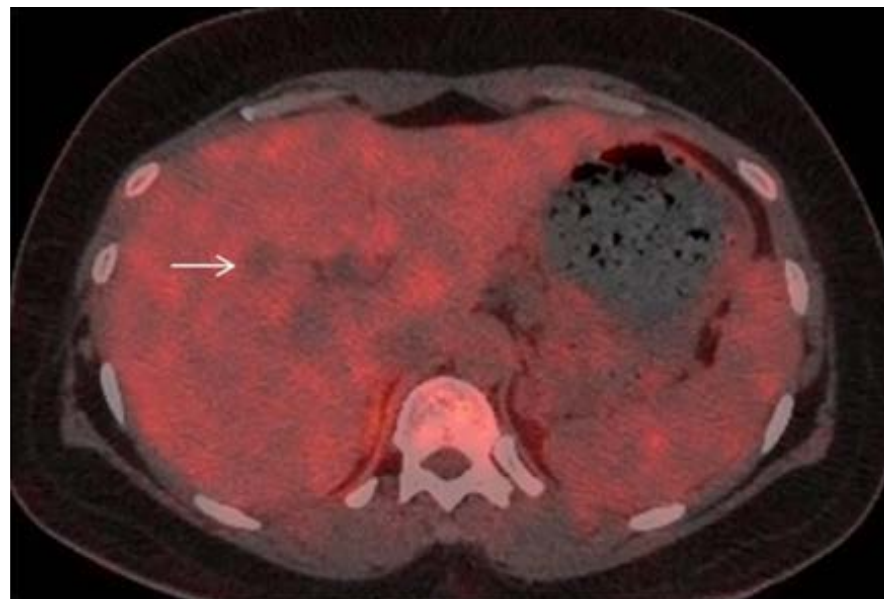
Axial fused images of PET CT scan shows no uptake in liver lesion (arrow)
